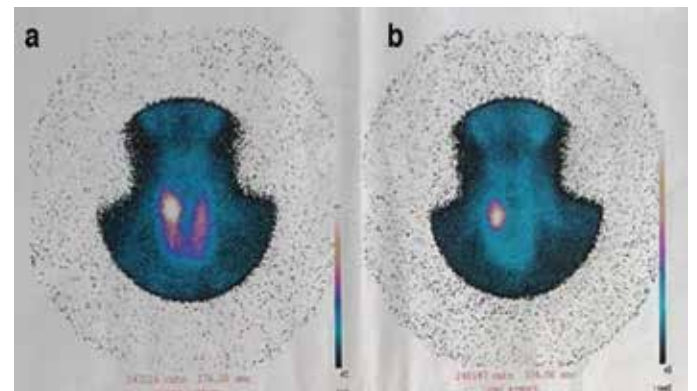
Technetium-99m-sestamibi SPECT shows an asymmetric uptake in superior aspect of right thyroid lobe
